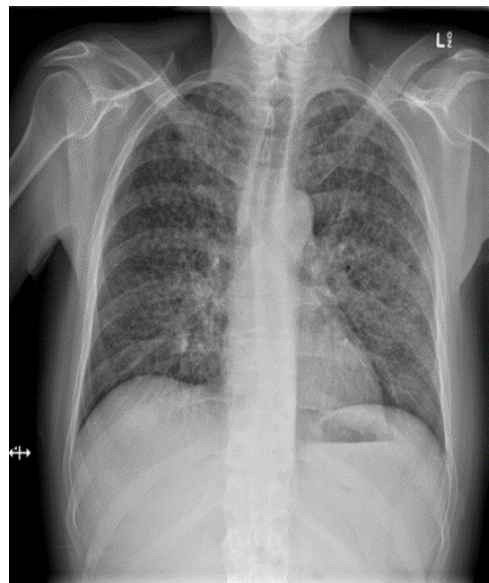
Chest X-ray showing miliary shadows.
